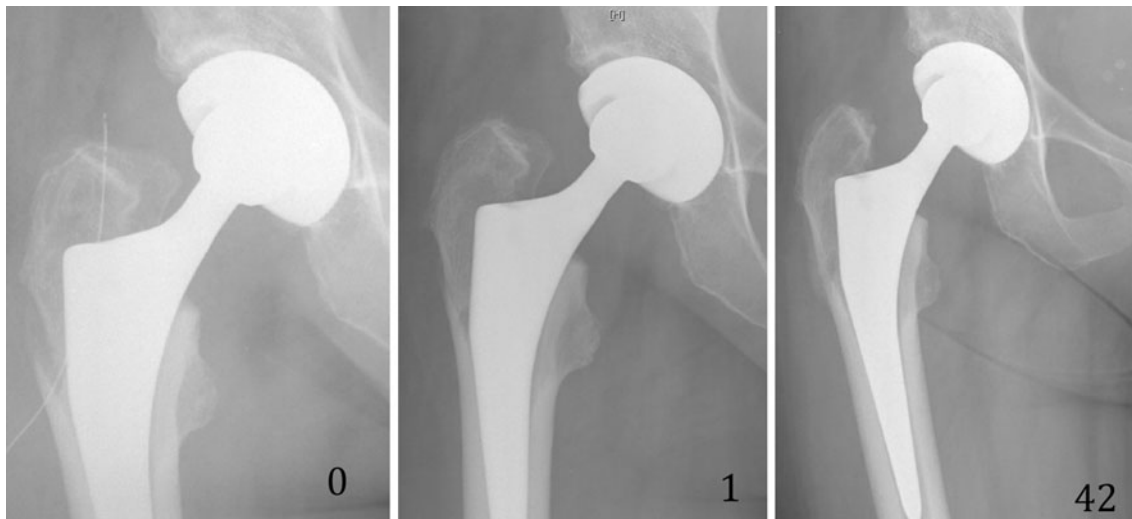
The radiographic appearance of a greater trochanteric fracture treated conservatively at 0, 1, and 42 weeks
